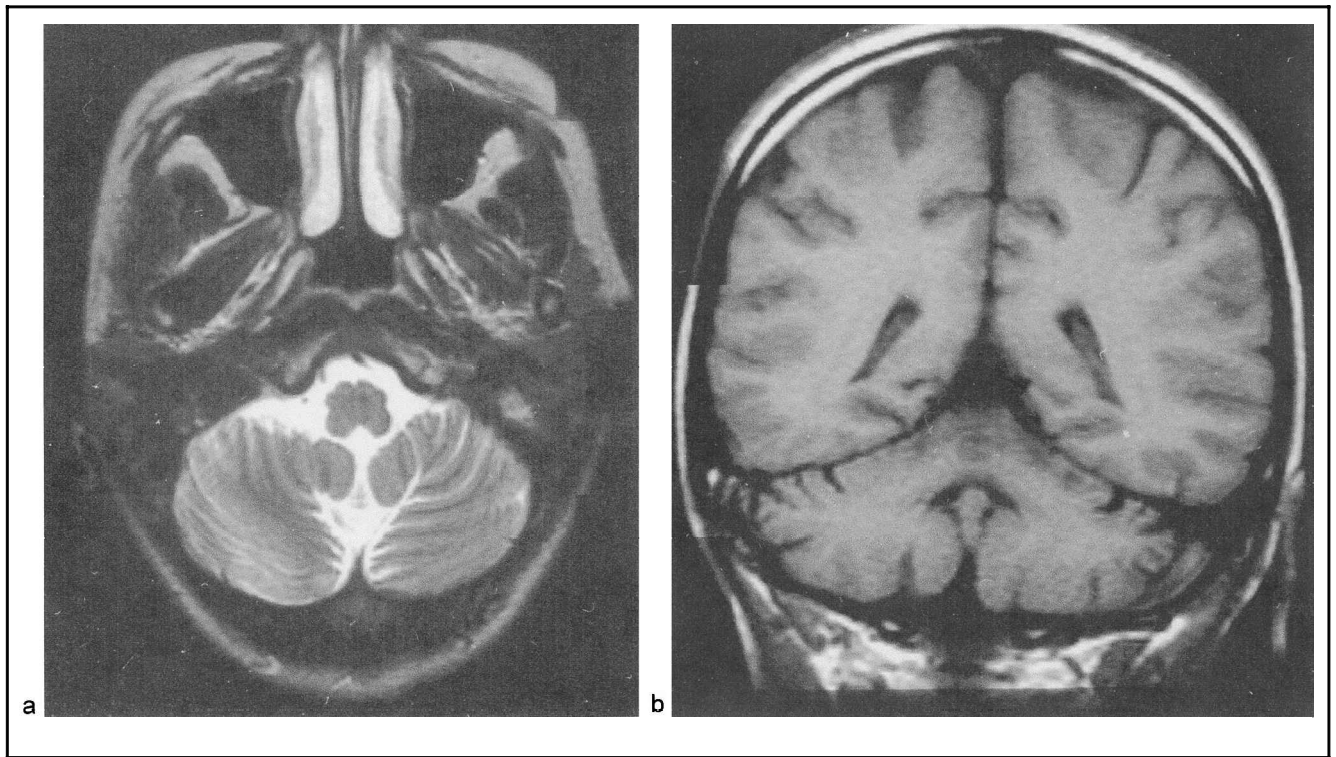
MRI scan of a typical patient with bilateral cerebellar atrophy.
